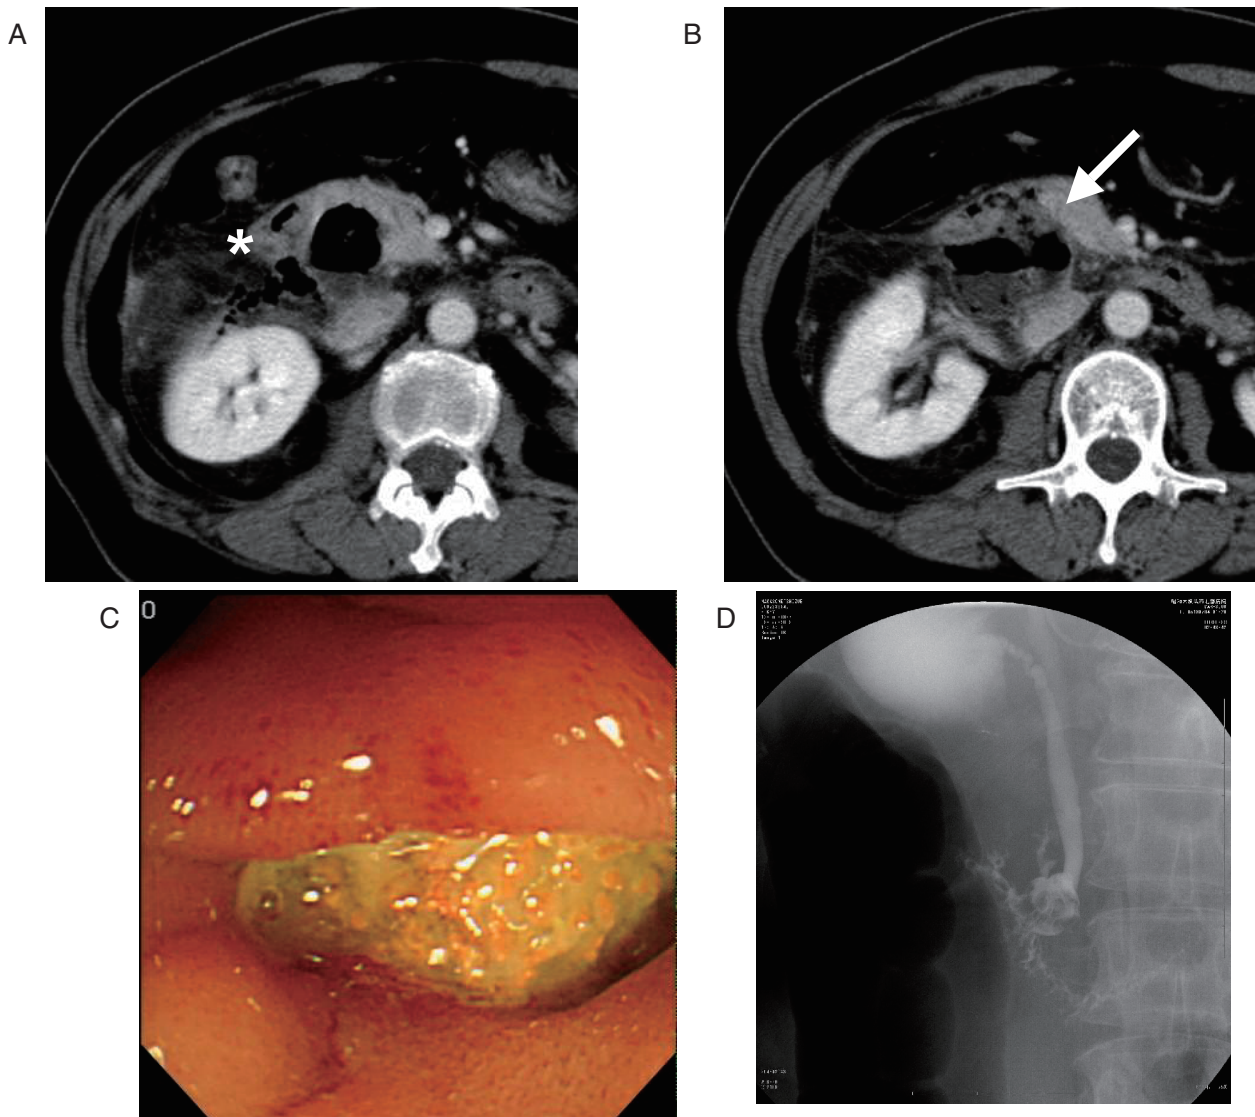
A 65-year-old man suffering from retroperitoneal perforation of a JPDD with an enterolith. Axial CT scans (A, B) show abnormal retroperitoneal air (asterisk) adjacent to a large JPDD with an enterolith (arrow). Endoscopy reveals a juxtapapillary diverticulum with an impacted enterolith (C). ERCP shows a filling defect within the diverticulum and extravasation of contrast medium into the retroperitoneal space (D).
